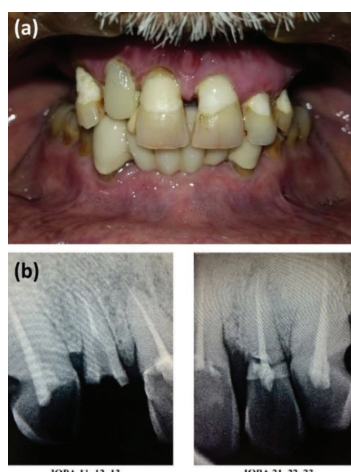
Preoperative View. (a) Intraoral Examination, (b) Radiographic Examination
